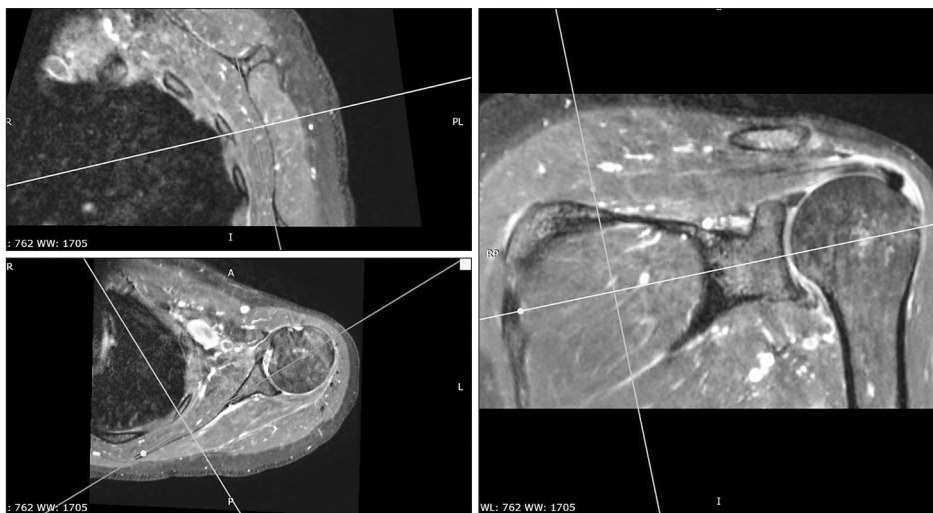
Reconstruction to scapular axis of normal magnetic resonance imaging (MRI). After setting the axial, coronal, and sagittal views of the MRI to be visible at the same time, we reconstructed the plane passing through the angular inferior, trigonum scapulae, and glenoid center of the scapular using the image analysis software (RadiAnt DICOM viewer). The scapular axis, which is perpendicular to this plane and is the line representing this plane in the axial plane passing through the glenoid center, was obtained.
